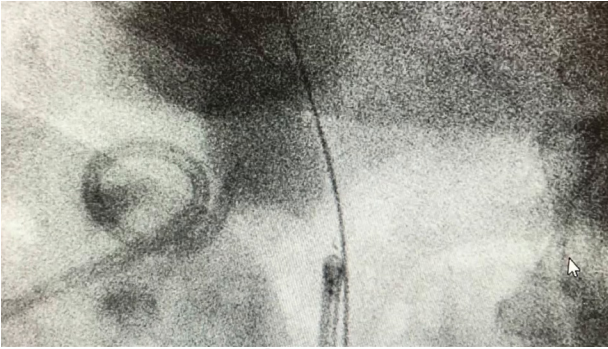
X-ray on the table confirming placement of right nephrostomy, with the large renal pelvis stone clearly visible.
